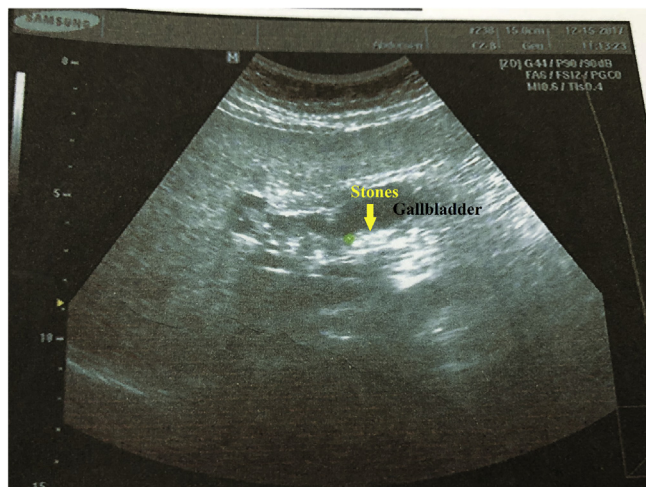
Abdominal Echography. This abdominal ultrasound documents a normal liver. The gallbladder wall is not thickened. However, cholelithiasis (arrow) is present; with some stones measuring 15x7 mm. The common bile duct and intrahepatic ducts are of normal caliber and stone-free.
